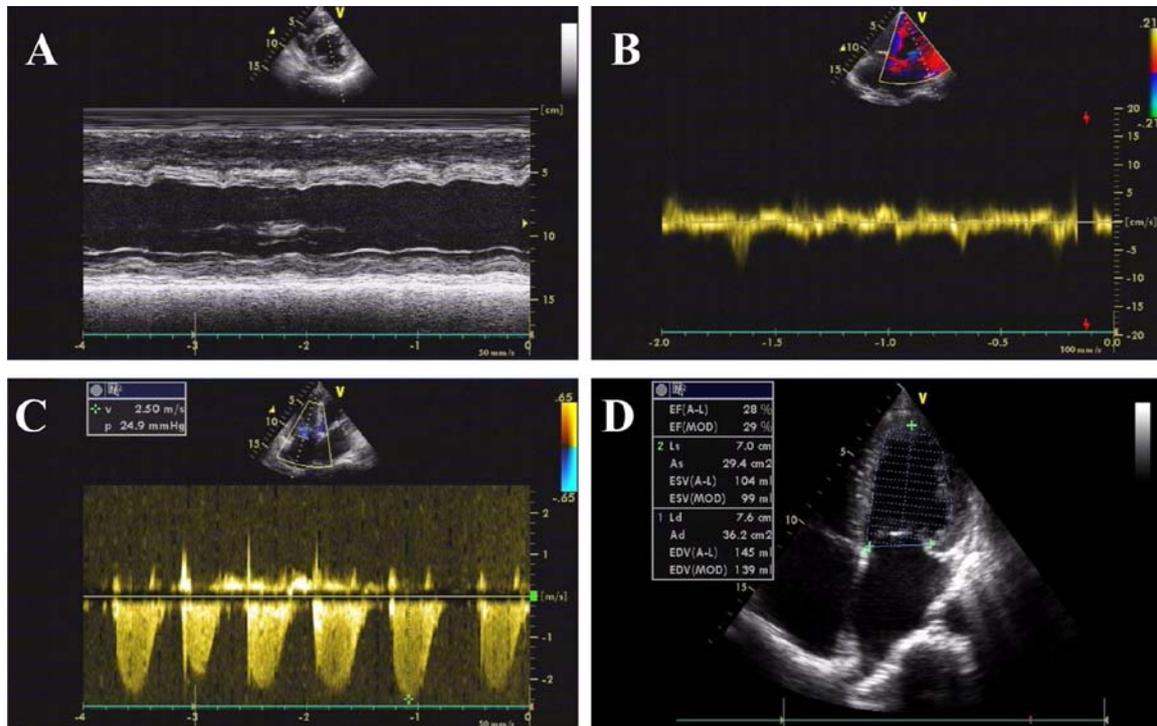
Characteristics of Cardiac echocardiography. The left ventricular wall dyskinesia, left ventricular hypertrophy, and decreased ventricular systolic function. Ejection fraction was 30%.
